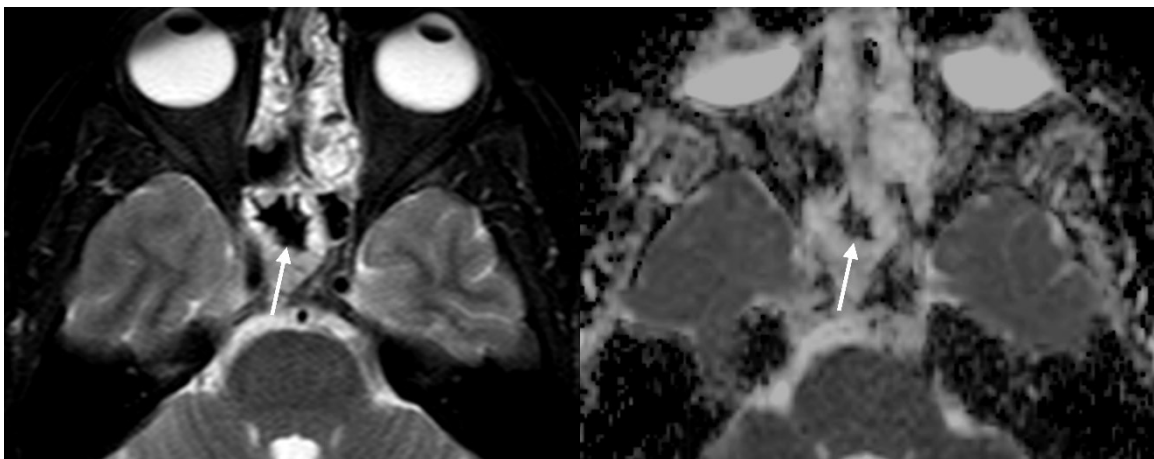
38-year-old female with allergic fungal rhinosinusitis. Fat-suppressed T2-weighted imaging (A) shows a markedly low signal in the right sphenoid sinus (arrow). The apparent diffusion coefficient value of the lesion was $0.53 \times 10^{-3} \text{ mm}^2/\text{s}$ (B, arrow).
